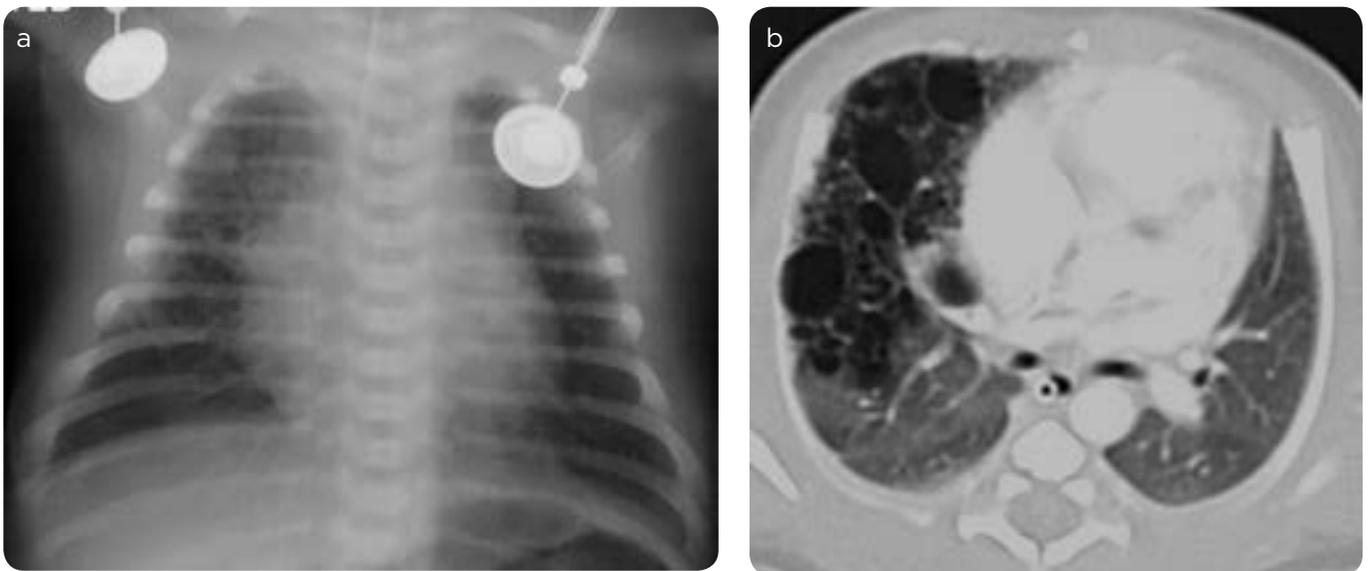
Adenomatoid cystic malformation type 2. Child 4 days old. a) Chest X-ray. Thin-walled radiolucent lesions in the right lung. b) Chest CT, axial. Upper and middle lobe mass consisting of multiple cystic-looking, thin-walled lesions.
